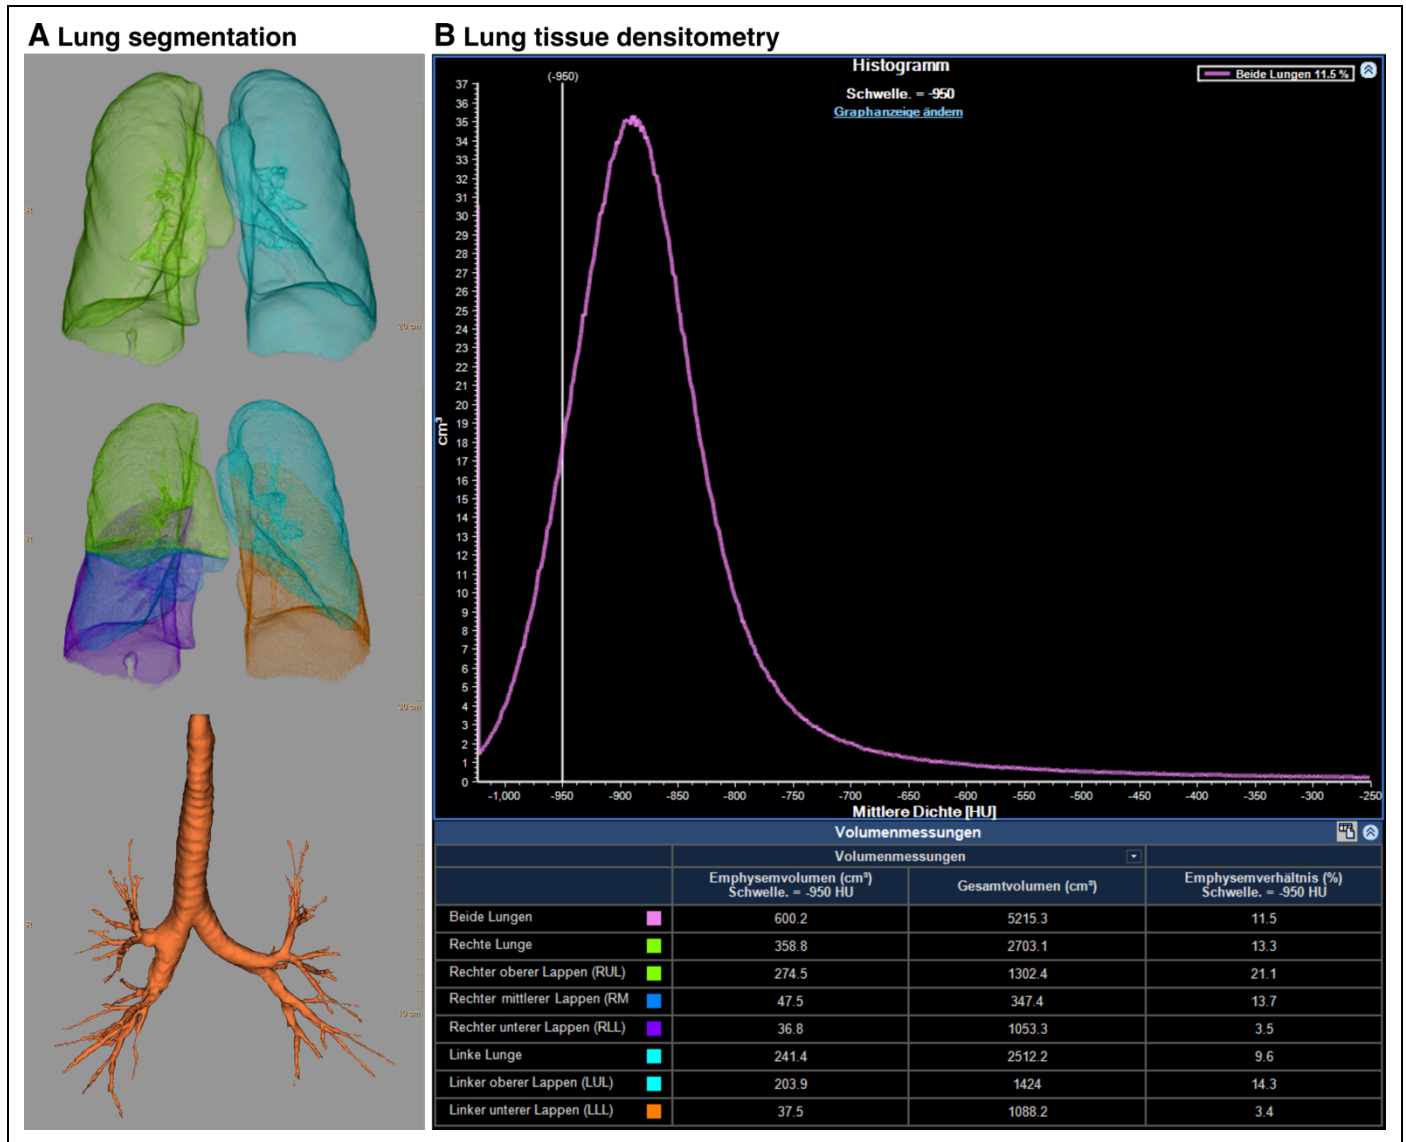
Screenshots of CT-based emphysema evaluation for the patient presented in figure 2. (A) shows the result of the segmentation of lungs, lobes, and bronchi. In (B), the density distribution within the segmented lung and a detailed listing of the emphysema index (rightmost table column), subdivided into lung side and lobes are depicted. The vertical line in the histogram denotes the threshold (-950 HU) for the evaluation. In the present case, 11.5% of the entire lung volume is classified as emphysematous.
